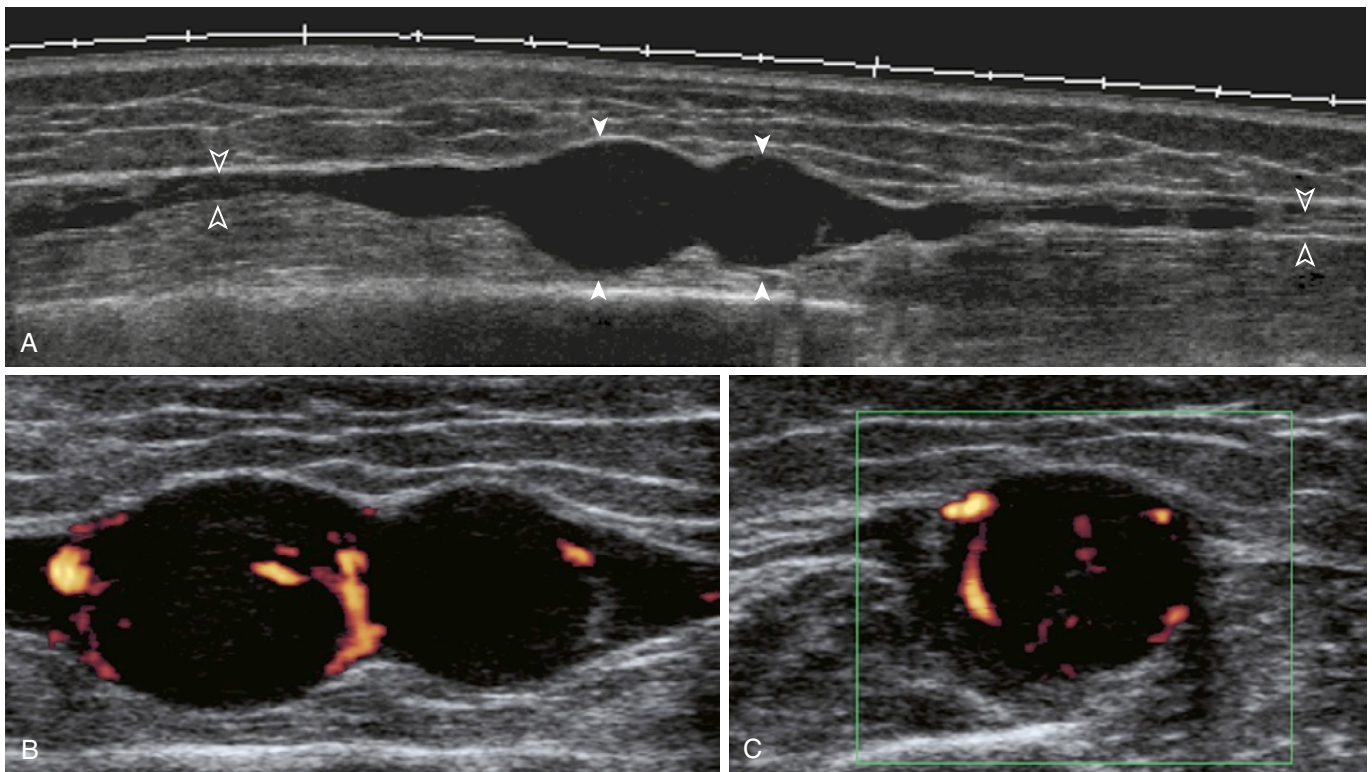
NEUROFIBROMA. A woman had neuropathic pain over the dorsum of the foot and a Tinel sign on the lateral middle-third of the leg. A and B, Long-axis, 5- to 14-MHz, extended-view ultrasound images over the superficial peroneal nerve in the lateral aspect of the leg show a bilobular, well-delimited, hypoechoic mass (*closed arrowheads*), with internal vascularization on power Doppler (B) and in continuity with the proximal and distal superficial peroneal nerve (*open arrowheads*). C, Short-axis power Doppler image shows the area.
